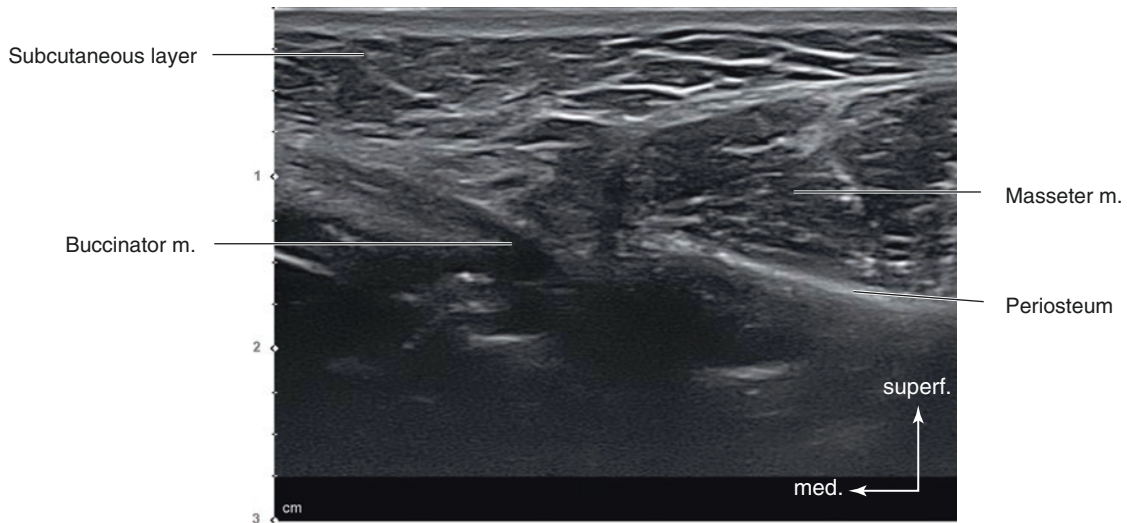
Ultrasonography of the anterior part of the masseter muscle, B mode (transverse view, 15 MHz by linear transducer). (Published with kind permission of © Ji-Soo Kim 2020. All Rights Reserved)
